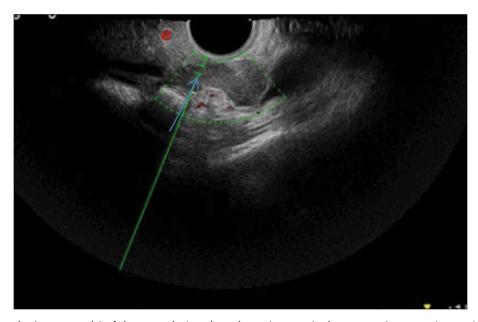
Dopplerography (energy mode) of the tumor lesion along the peritoneum in the retrouterine space in a patient with stage IIIC serous ovarian cancer.
